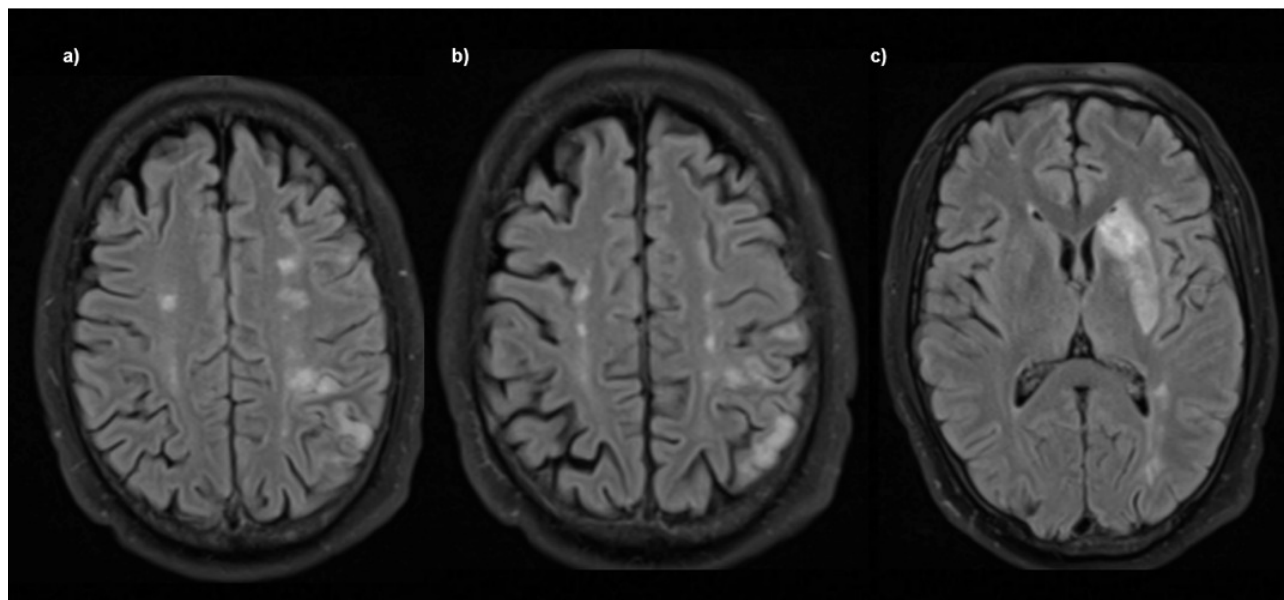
Magnetic resonance imaging.
